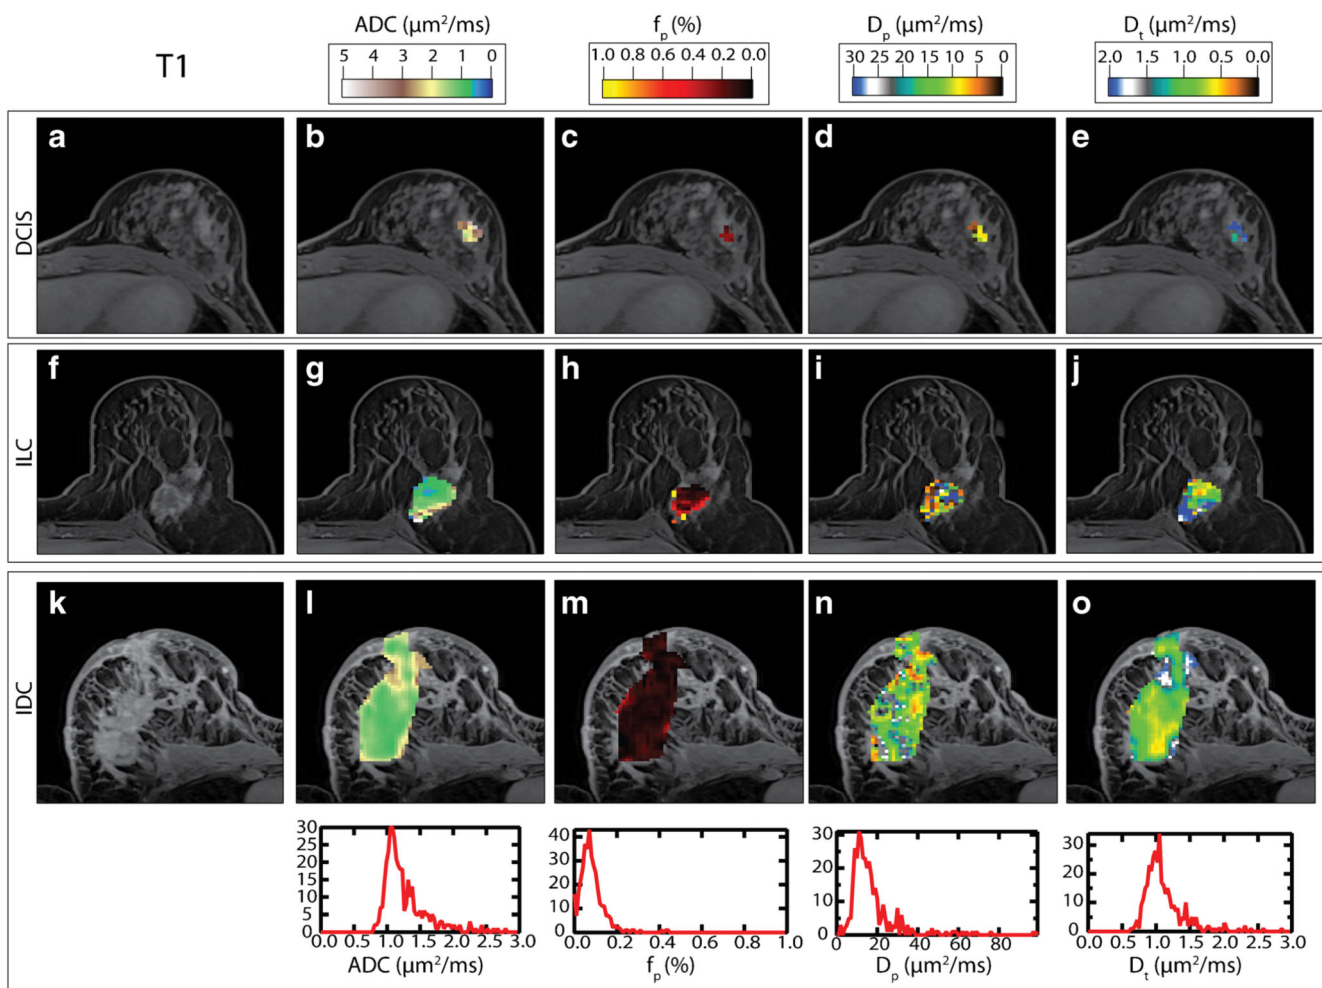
ADC and IVIM parameter maps (f_p , D_p , D_t) superimposed on contrast-enhanced T1-weighted MRI within ROIs containing breast tumours. Patient 1 (a–e) is a DCIS 53-year-old patient. Patient 2 (f–j) is a 59-year-old ILC patient. Patient 3 (k–o) is an IDC 62-year-old patient, with the corresponding whole-volume histograms below each of Patient 3’s parameter map
